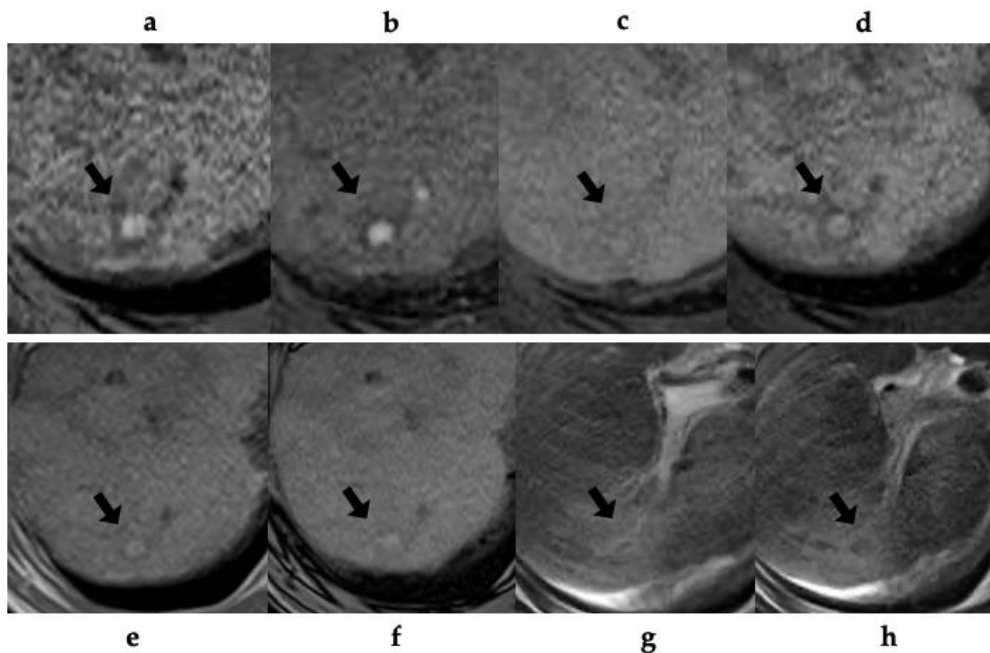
A 65-year-old man with alcoholic liver cirrhosis (patient no. 8). (a-b) T1-weighted gradient-echo (GRE) MR (a; in-phase, b; opposed-phase) image shows a small and high-signal-intensity nodule (arrow) in segment 7 of the liver. (c) pre-contrast T1-weighted GRE MR imaging shows iso-slightly high-intensity nodule (arrow). Gadoxetic acid-enhanced T1-weighted GRE MR imaging obtained during the (d) arterial- and (e) portal-venous phase reveal a nodule with arterial phase hyperenhancement (arrow) and without washout (arrow). (f) The hepatobiliary phase of the gadoxetic acid-enhanced T1-weighted GRE MRI shows homogeneous high-intense uptake (arrow). (g) T2*-weighted GRE MR image shows iso-intensity nodule (arrow). (h) The SPIO-enhanced T2*-weighted GRE MR image shows the lesion as a low-signal intensity nodule (arrow) with SPIO-uptake compared with the surrounding liver parenchyma.
